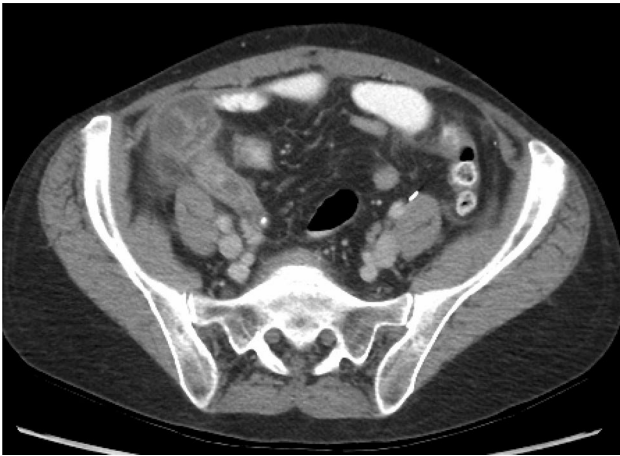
47-year-old female who presented with right lower quadrant pain. Initial TVUS (not shown) was interpreted as normal, but CT demonstrated a dilated, fluid-filled, thick-walled enhancing appendix with appendicolith, compatible with acute uncomplicated appendicitis
